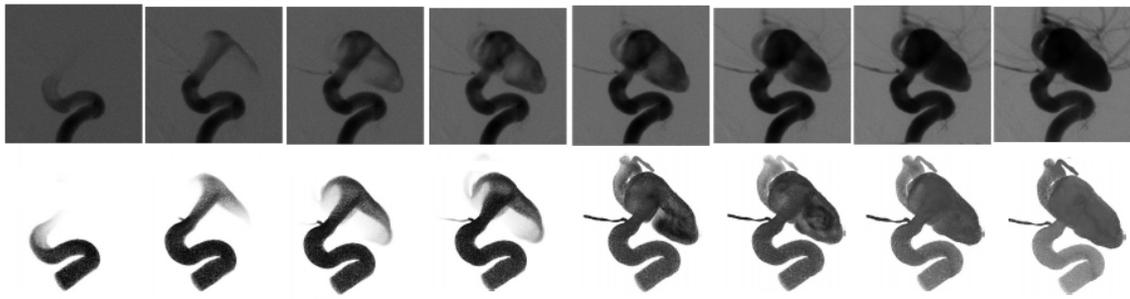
The uptake of dye observed angiographically (top) was compared to what was predicted from CFD (bottom) under pulsatile flow (time progresses from left to right). The geometry was reconstructed from a CT scan of the patient. [100]
